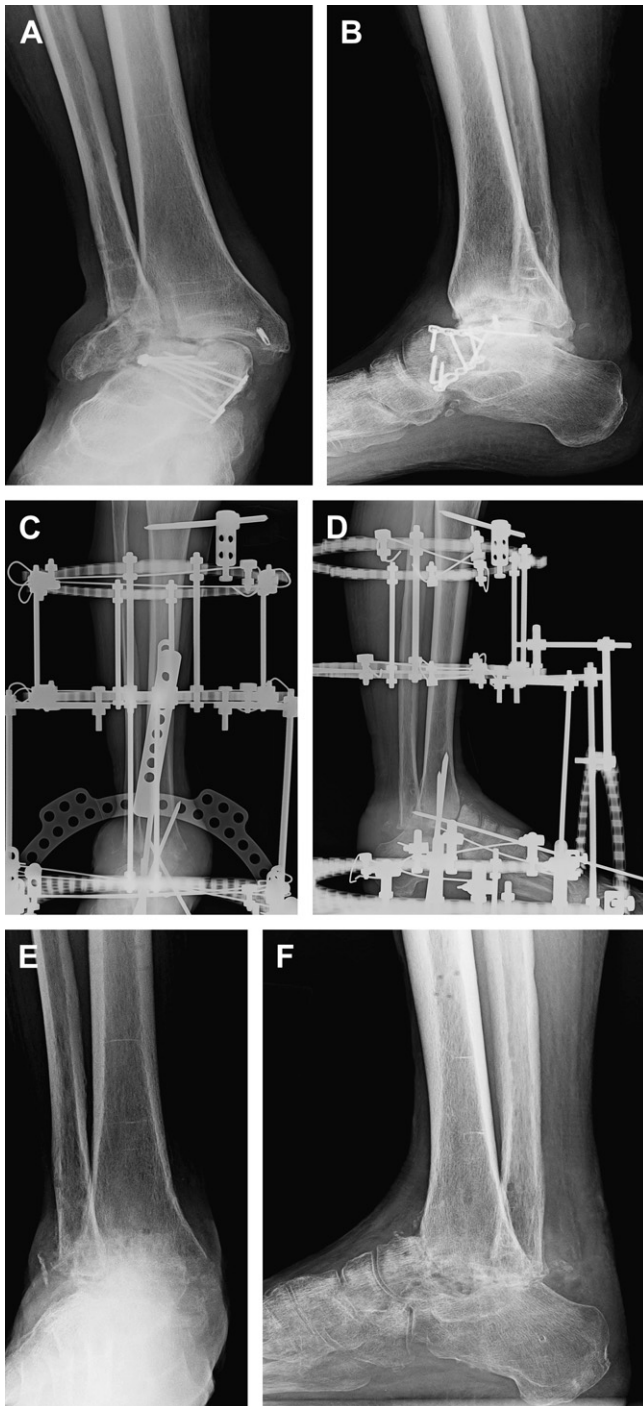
Preoperative anteroposterior and lateral ankle radiographs (A, B) showing the avascular necrosis of the talus with collapse and nonunion of the lateral malleolus with significant valgus deformity and loss of talar height after an open reduction and internal fixation. Postoperative anteroposterior and lateral ankle radiographs (C, D) at 2 weeks showing the tibio-calcaneal arthrodesis alignment in 1-stage talectomy with circular external fixation. Postoperative anteroposterior and lateral ankle radiographs (E, F) at 1-year follow-up demonstrating successful alignment and union of the tibio-calcaneal arthrodesis.
